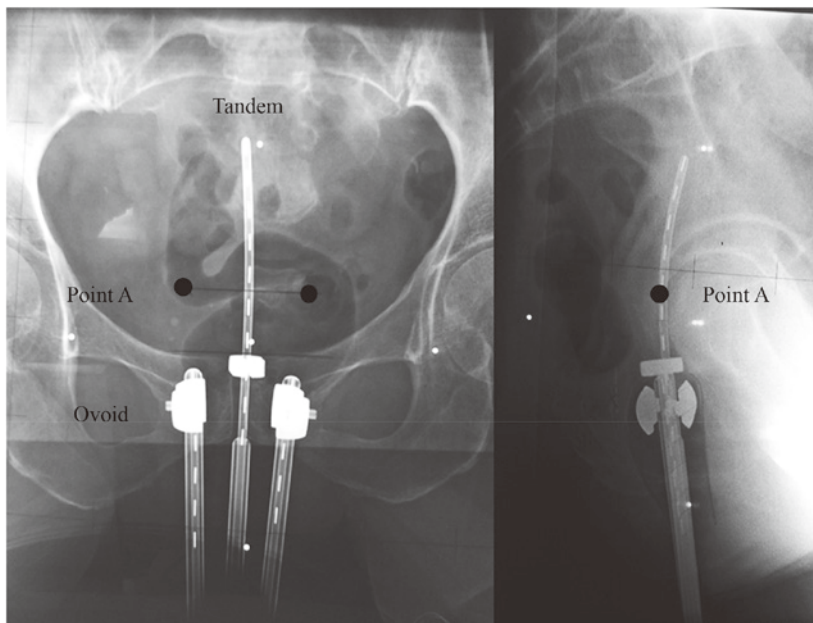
Point A using the plain X-ray films
